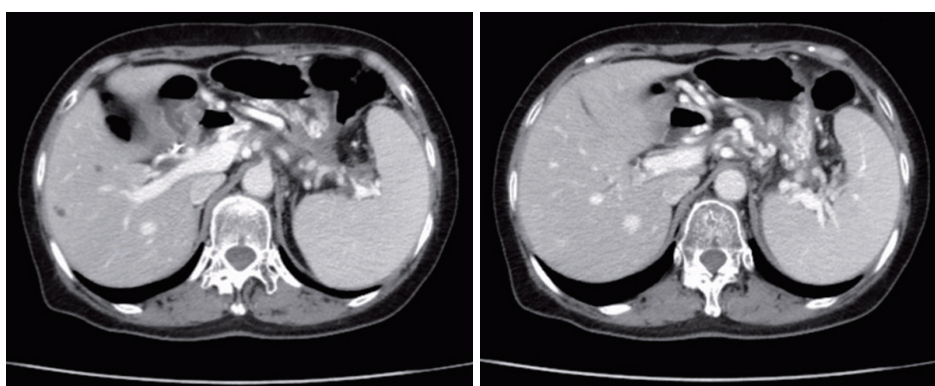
Follow-up contrast-enhanced computed tomography scan images. Contrast-enhanced computed tomography of the abdomen demonstrating that the pseudocyst was completely resolved three months after stent removal. No recurrence was noted, as indicated by the significant resolution of the serious perisplenic and gastric varices.
